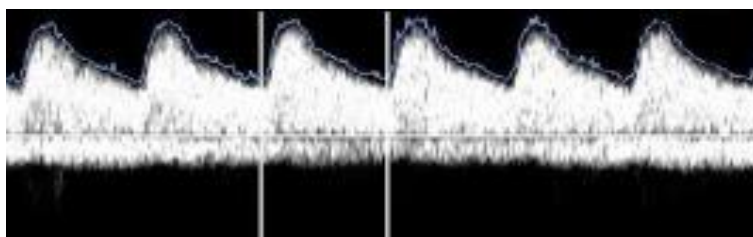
FIGURE III B : NORMAL UMBILICAL ARTERY DOPPLER
